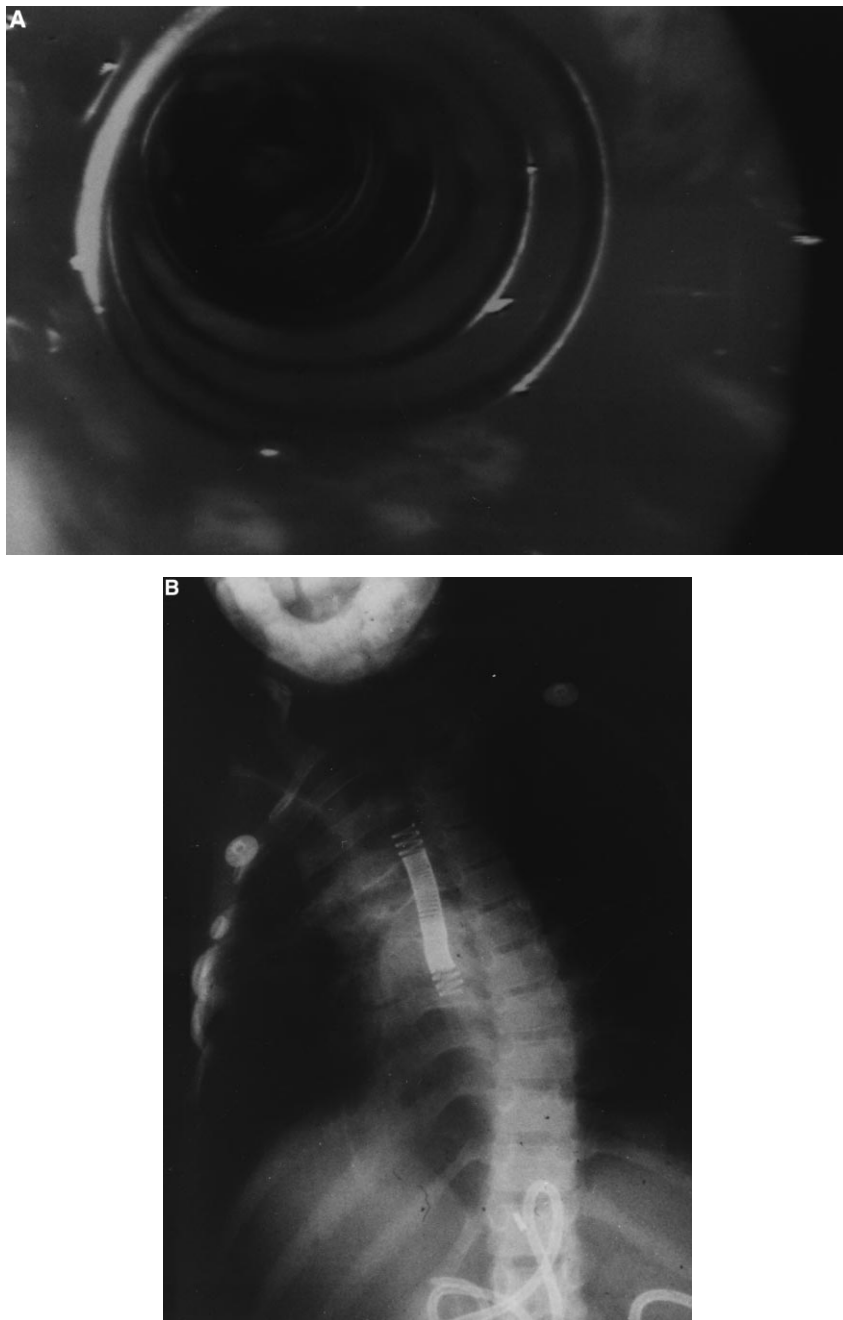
(A) Esophageal stent positioned within the stricture. (B) Chest X-ray showing final position of stent.
